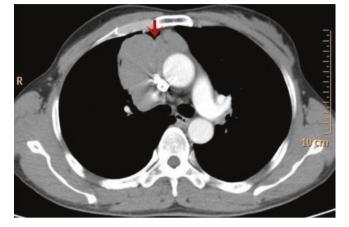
A 59-year-old woman with type B1 thymoma. Chest CT showed a complete capsule and clear mediastinal fat plane (red arrow)
